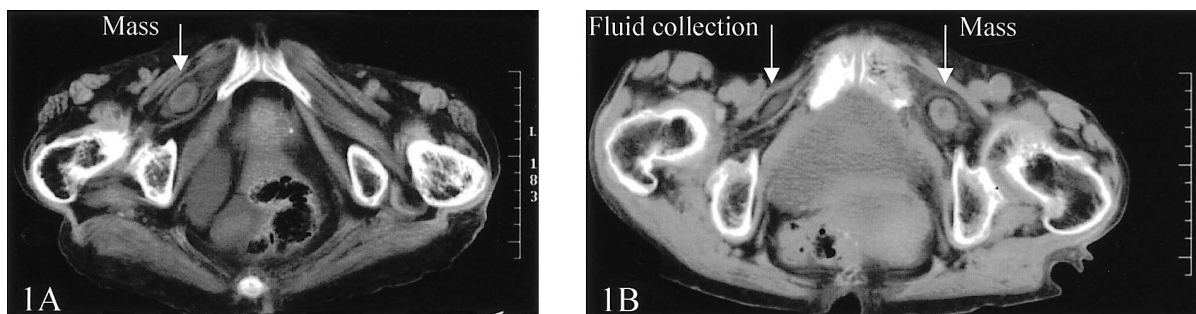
Computed tomography of strangulated obturator hernia. (A) Computed tomography (Table 1, Patient No. 4) reveals a mass lying between the obturator externus and pectineus muscles. (B) Computed tomography (Table 1, Patient No. 6) reveals a mass on the left side and a fluid collection on the right side.
